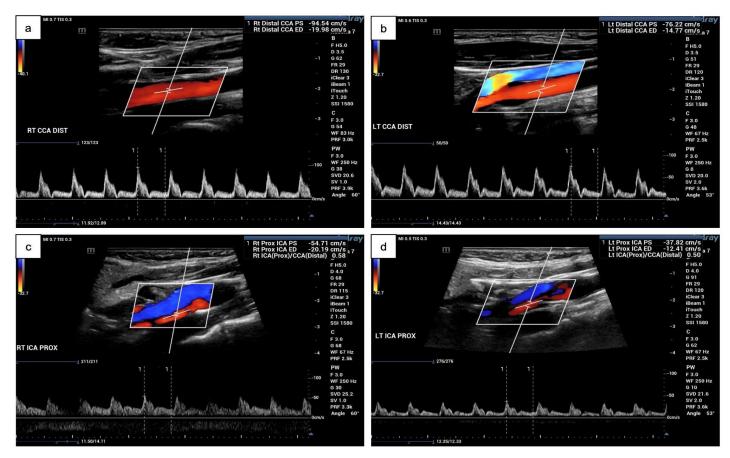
Extracranial duplex ultrasound, longitudinal field, demonstrating (a) normal right common carotid artery, (b) normal left common carotid artery, (c) attenuated flow with uniform small caliber in the right internal carotid artery, and (d) attenuated flow with uniform small calibern the left internal carotid artery.
